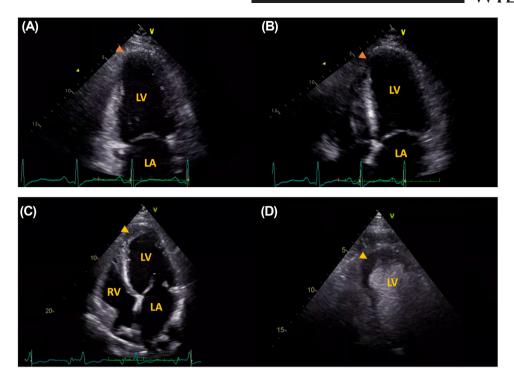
(A,B) Apical 2- and 4-chamber views, respectively, showing LV dilatation and bulbous apex, with apical, distal anterior, and septal wall thinning (orange arrowheads); (C,D) apical 4-chamber view showing apical thrombus (arrowheads) without (C) and with contrast-enhancement (D). LA, left atrium; LV, left ventricle; RV, right ventricle
